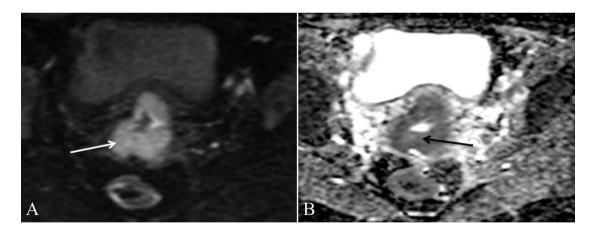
Diffusion weighted MRI (A) of cervix showing hyperintense signal (white arrow) which on corresponding ADC mapping (B) showing restricted diffusion (black arrow).
